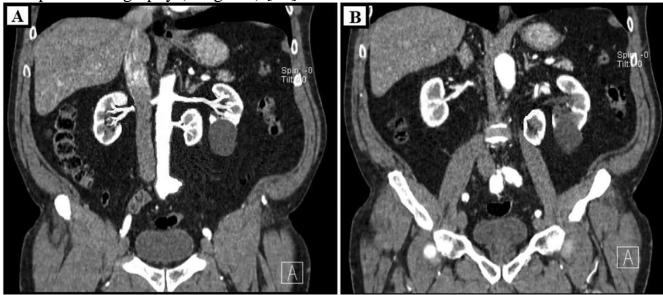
CT scan (arterial phase, the separate ectopic supernumerary left kidney which have own blood supply from aorta) [14].
